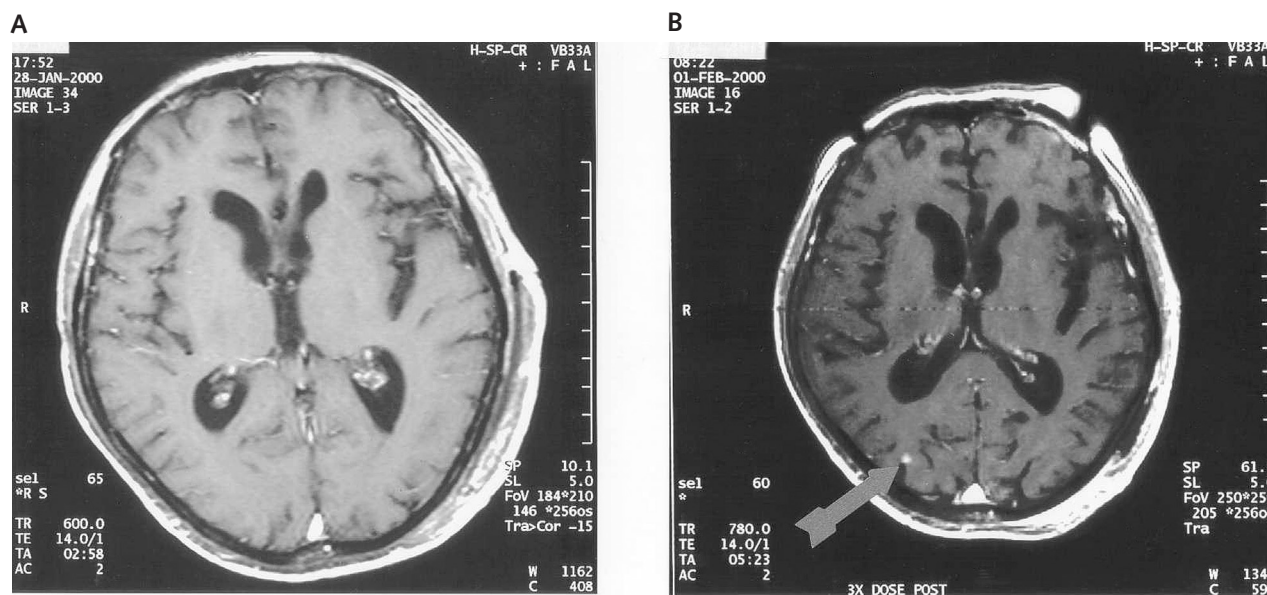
MR imaging to reveal lesion in right occipital pole. A. Conventional single-dose gadolinium enhanced MR at time of initial evaluation. B. Triple-dose MR obtained on day of gamma knife planning (as evidenced by fiducials) showing a contrast enhancing lesion in the right occipital pole that was not visualized 4 days earlier on conventional imaging. Review of this lesion in sagittal and coronal imaging verified that this was not a vessel.
